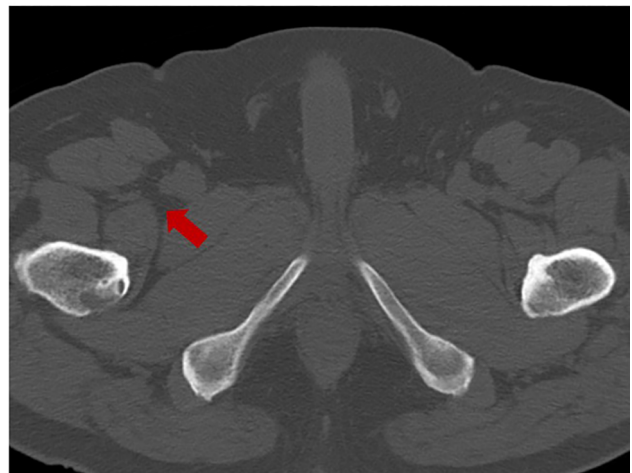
Computed tomography image showing cortical bone thinning and destruction at the lesser trochanter.
